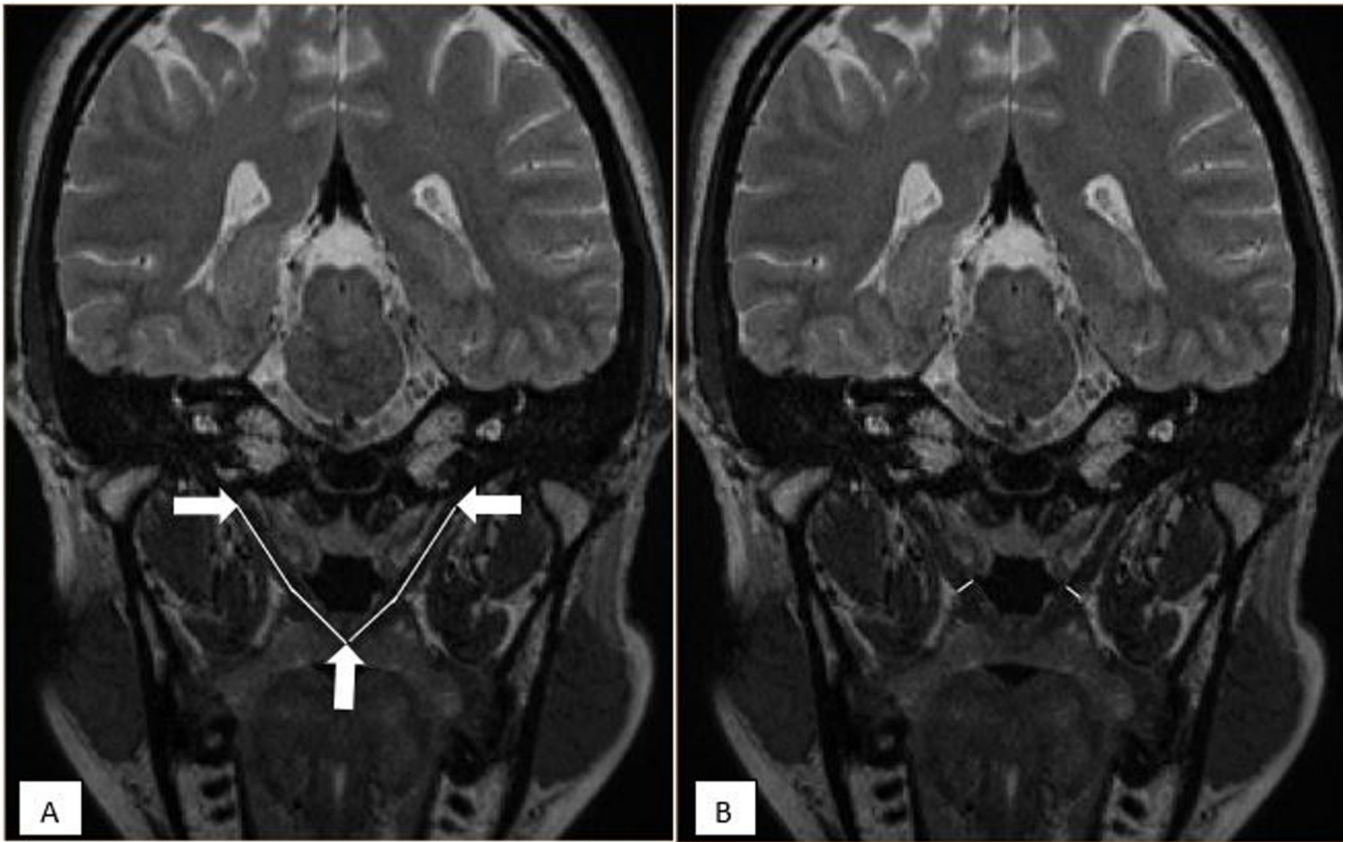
The levator muscle. A, Magnetic resonance imaging of the oblique coronal plane displaying the levator muscle and the measures obtained on the muscle. The entire length of the muscle bundle represents from origin to insertion at the velar midsection. B, Magnetic resonance imaging of the oblique coronal plane displaying the levator muscle and the measures obtained on the muscle. The white lines depict the thickness for the right and left portion of the levator muscle bundles.
